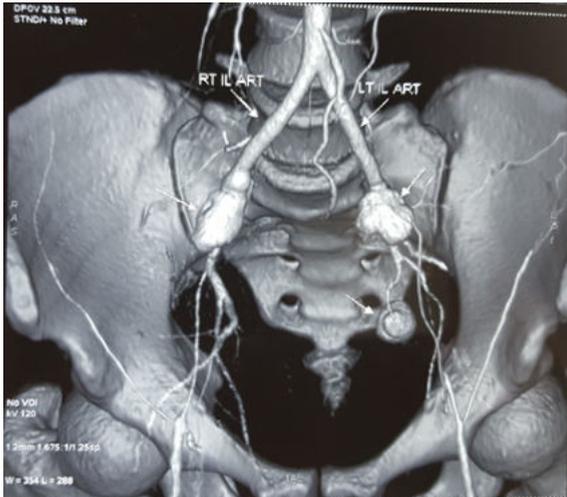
CT angio pic of patient with bilateral CIA aneurysm with distal occlusion.
